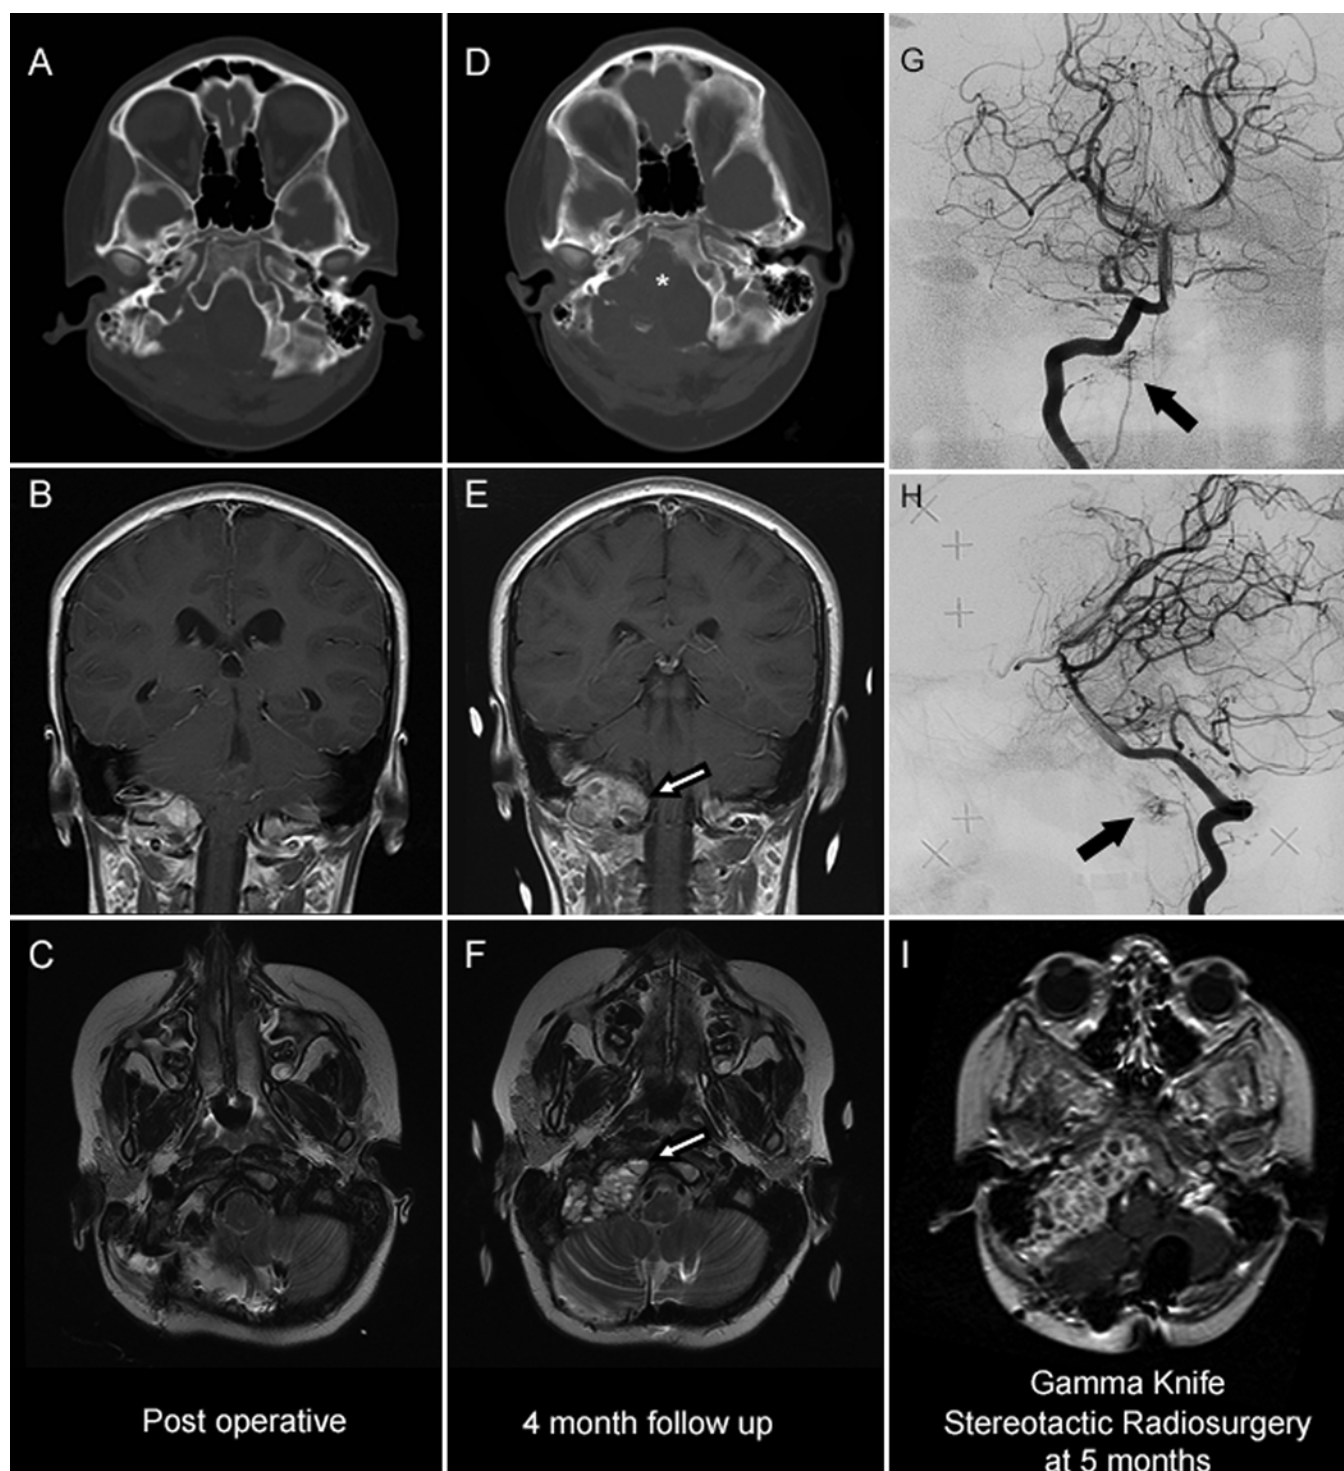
Postoperative imaging (A–C). Bone window in unenhanced CT (A), enhanced T1-weighted MRI (B), and T2-weighted MRI (C) demonstrating residual abnormality in the petrous temporal bone. Early 4-month follow-up after presentation with new diplopia and torticollis (D–F). D: Bone window CT demonstrating progressive erosion of the right occipital condyle and clivus (*asterisk*). E: Expanding soft-tissue abnormality in the right occipital condyle (*white arrow*). F: The progressive residuum demonstrates new cystic areas with fluid-fluid levels (*white arrow*) similar to those in the presentation lesion. Angiography for GKRS planning performed at 5 months postsurgery (G–I). G: Anteroposterior view of the tumoral blush (*black arrow*). H: Lateral view of angiogram again demonstrating tumoral blush (*black arrow*). I: Further progression of the avidly enhancing solid cystic lesion into the clivus at the time of GKRS.
